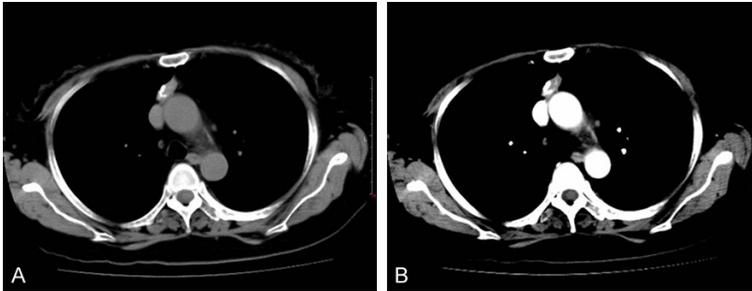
Imaging features of sclerosing thymoma. A. Unenhanced Computer tomography (CT) scan revealed an anterior mediastinal mass with oval shape, relative smooth margins and focal high density. B. Contrast-enhanced CT scan demonstrated heterogeneous enhancement.
